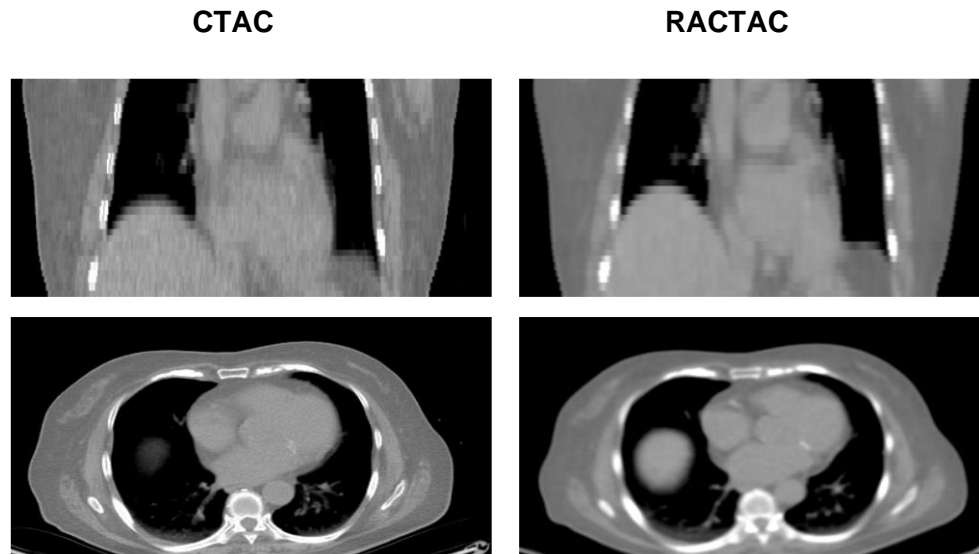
Standard attenuation map-CTAC (right) vs respiratory average CT attenuation maps-RACTAC (left). Coronal (top) and transverse (bottom) images.
